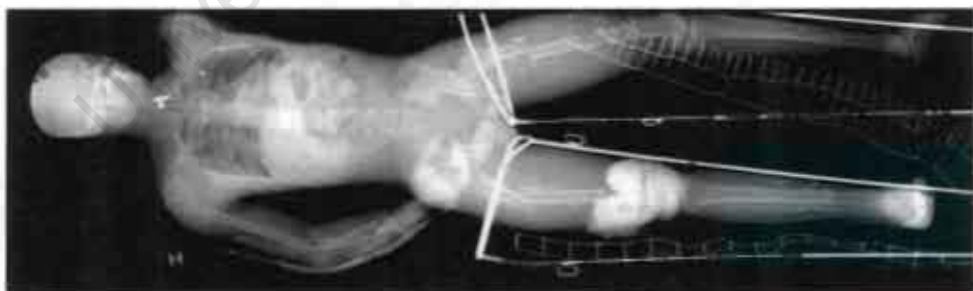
An example of a full-body digital Statscan X-ray image of a trauma patient with multiple injuries (Beningfield *et al.*, 2003)
